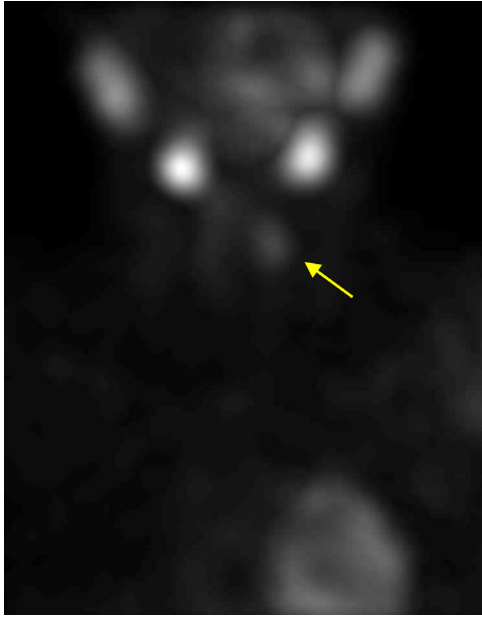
Tc99m-sestamibi scintigraphy showed increased tracer uptake at the left superior parathyroid gland (arrow).
